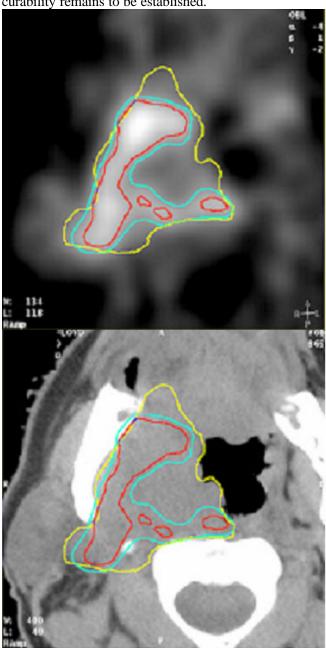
Cu-ATSM identified hypoxic region and the corresponding CT area.
